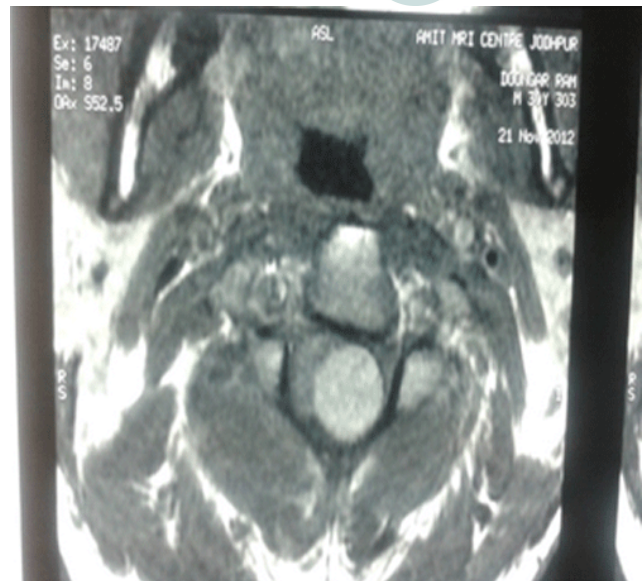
MRI of cervical spine, transverse plane. MRI: Magnetic resonance imaging
